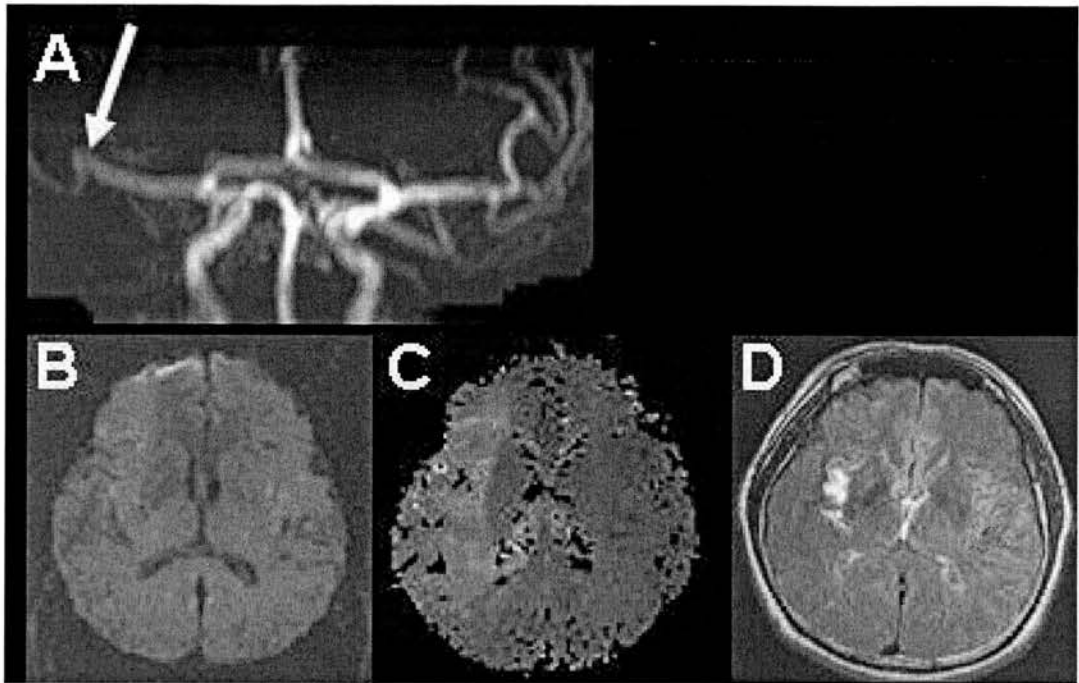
Case 4. 60 year old man who developed left sided weakness and dysarthria. He improved en-route to hospital and on arrival in the ER he had a NIHSS of three. MRA showed attenuated flow (white arrow) at the MCA bifurcation (A) with complete occlusion of the superior M2 division and diminished flow in the inferior M2 division. His DWI imaging initially showed no evidence of a lesion. (B). PWI showed a large area of Mean Transit Time (MTT) delay (C). He had a fluctuating clinical course over the next 24-48 hours, with a NIHSS varying between three and six. He was treated with volume therapy, did not deteriorate further and at 30 days had a follow up scan. FLAIR (D) shows right insular infarction. He was functionally independent and had a NIHSS of two.
